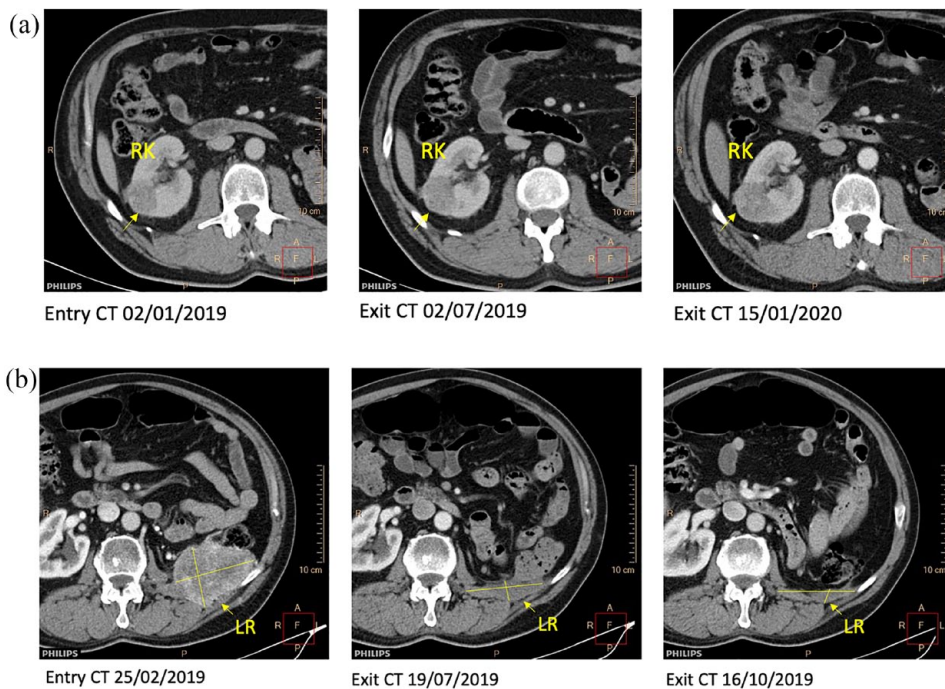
CT findings of patients with long-term MitoTam therapy. (a) Stable disease of the target lesion in the right kidney (RK) in patient P1-1.0. This lesion is marked as 'right kidney 1' in Figure 3. (b) Partial response of the local recurrence after left nephrectomy in patient P6-1.0. This lesion is marked as 'local recurrence' in Figure 5. CT, computed tomography.
